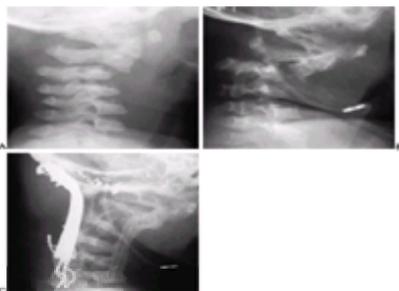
A: Lateral cervical spine radiograph of a 9-month-old boy with neurofibromatosis. Note the preexisting cervical kyphosis at C2-C3. At the age of 3 years he underwent a suboccipital craniectomy and cervical laminectomy from C1 to C4 for resection of neurofibromata. B: By the age of 3 years, 10 months, he had developed a 90-degree kyphosis. C: He underwent combined anterior cervical fusion from C2 to C6 with a fibular strut graft, and posterior cervical fusion from the occiput to C6 with internal fixation provided by a Luque U-rod. Three years postoperatively solid fusion, with a residual 70-degree kyphosis, is present.
